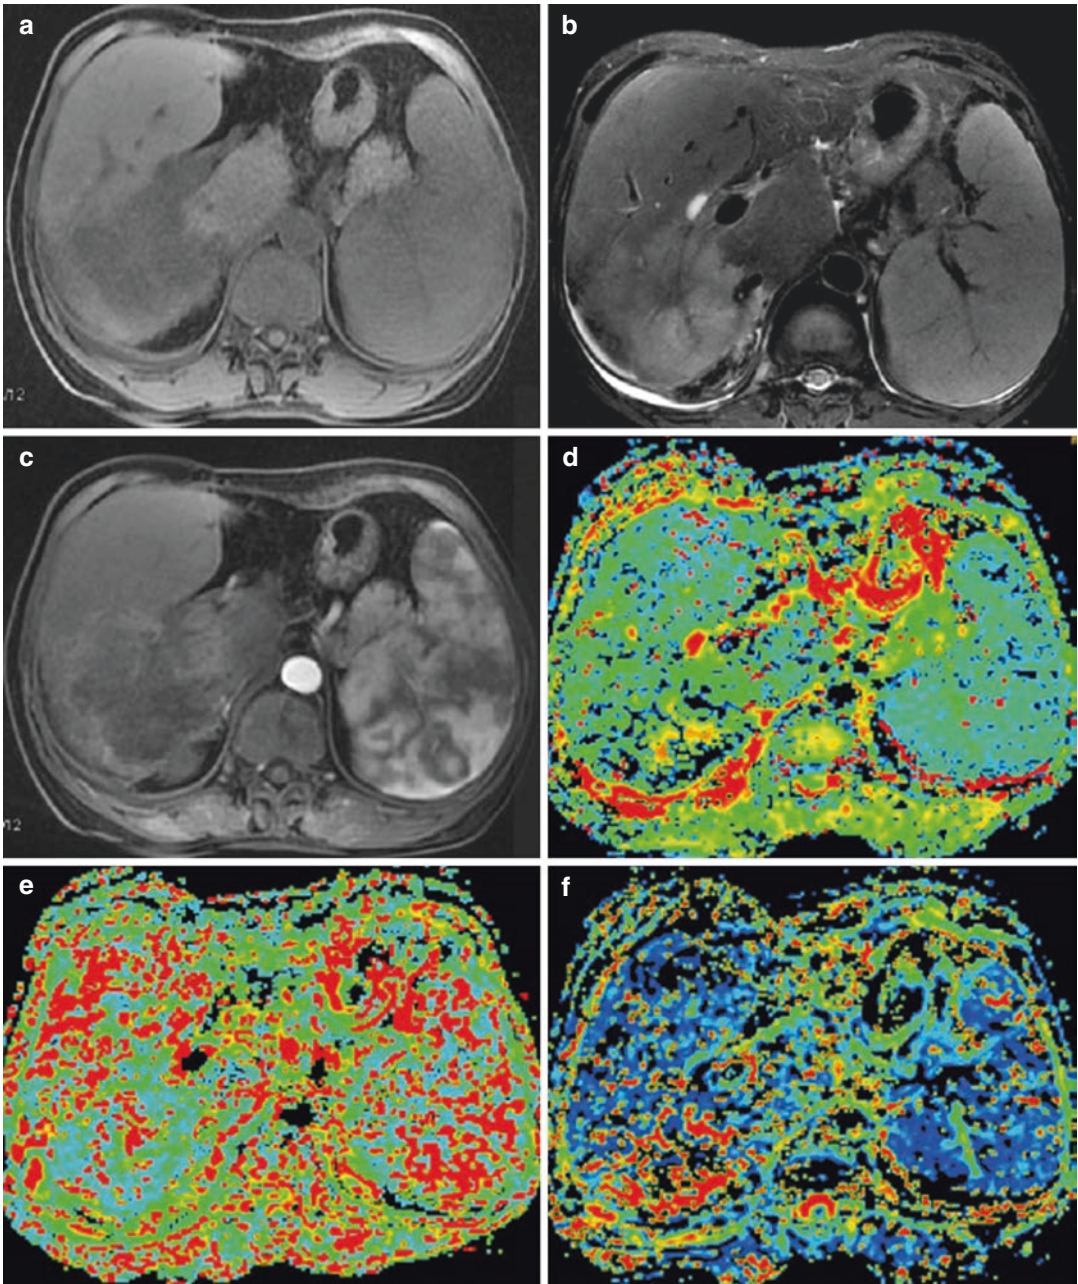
53-year-old woman with hepatocellular carcinoma in the right lobe of the liver. (a) Axial T1-weighted image shows a hypointense mass in the posterior right lobe of the liver; (b) axial T2-weighted image shows a hyperintense mass; (c) contrast-enhanced MRI during the arterial phase showing lesion enhancement; (d) mapping of the estimated value of the true molecular-diffusion coefficient (D parameter). The average value in the lesion
